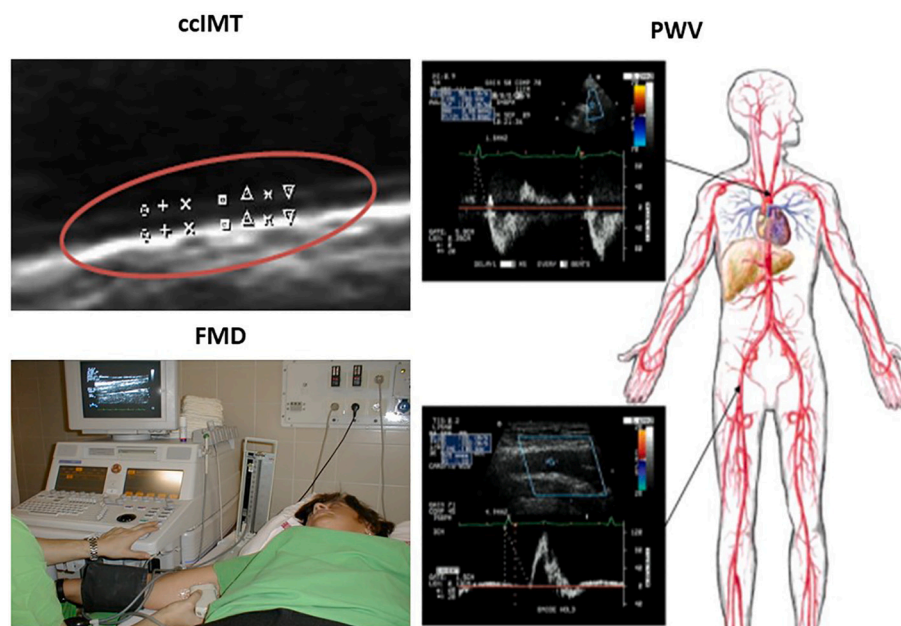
Ultrasound-based, non-invasive techniques for the assessment of vascular pathophysiology. Common carotid intima-media thickness (ccIMT) is a measure of overt atherosclerosis. The distance between the first and second echogenic line from the lumen compose the ccIMT. Flow-mediated vasodilation (FMD) of the brachial artery is an indicator of endothelial function. It shows the percentage of the dilation of the artery, which is impaired (lower) in the case of endothelial dysfunction. Arterial pulse-wave velocity (PWV) is a marker of vascular stiffness. The distance used for this measurement is between the jugulum and symphysis.
